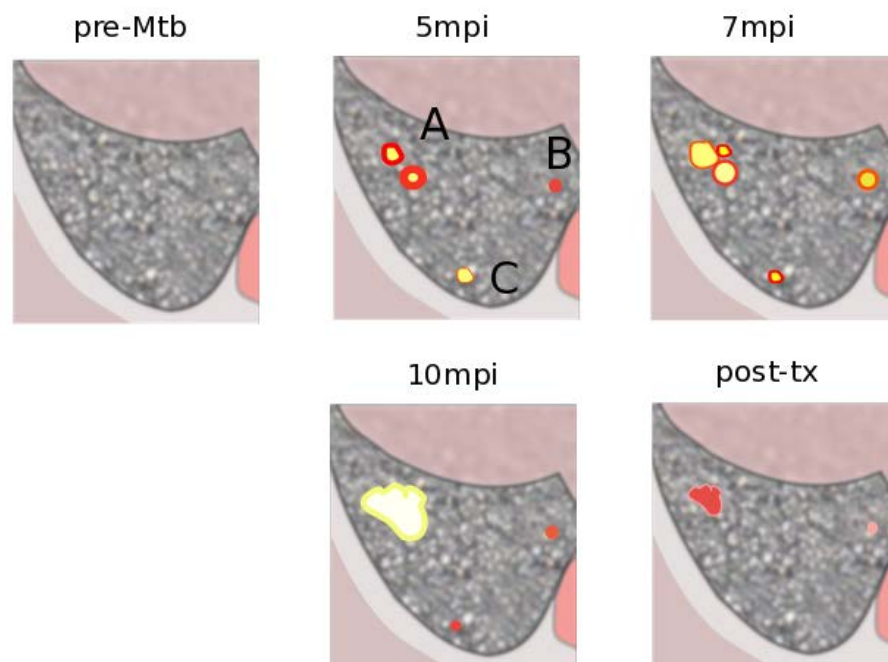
Hypothetical PET/CT image showing granuloma dynamism throughout time
